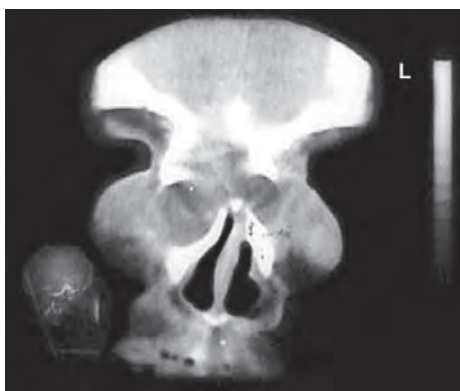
CT scan of head of an 8-year-old child which shows bilateral naso-orbital encephalocele
